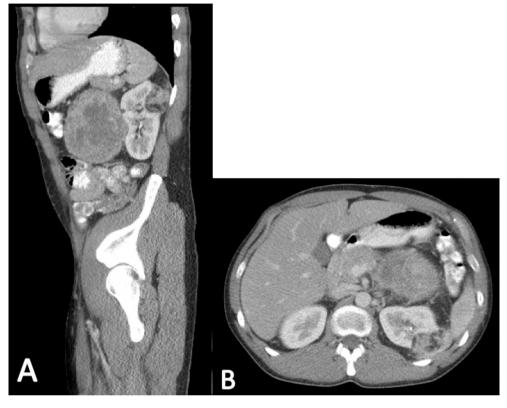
A: Computed Tomography sagittal view of extrarenal PEComa anterior to left kidney with an intrarenal angiomyolipoma. B: Computed Tomography axial view of extrarenal PEComa anterior to the left kidney.
